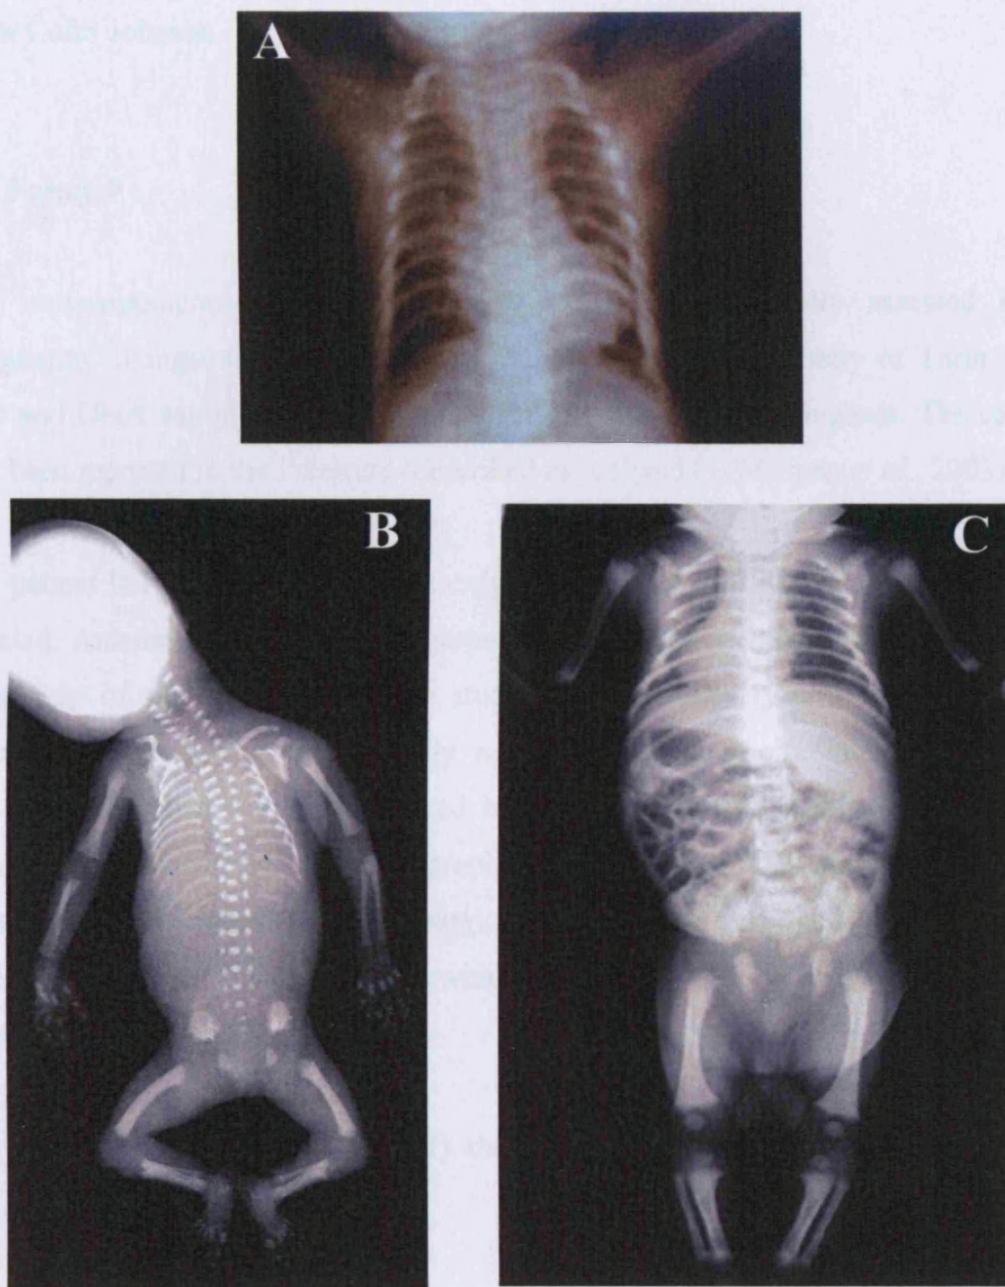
Radiographs of patients II.3 from Family 7 (A), II.1 from Family 8 (B) and II.1 from Family 9 (C). Patients have a small thorax with short ribs. Proband II.1 from Family 8 (B) has medial and lateral spurs on the acetabular roofs and additional lateral spurs on the iliac wings. Mesomelic shortening of the lower limbs with some cupping of the metaphyses is also present. Femurs are mildly curved. In the hands, there is shortening of the middle phalanges and metacarpals, but no polydactyly. Proband II.1 from Family 9 (C) has mild narrowing of the thorax and horizontal acetabular roofs with spur-like projections. There is rather severe mesomelic limb shortening and significant irregularity of the distal ends of the femora with flared metaphyses.
